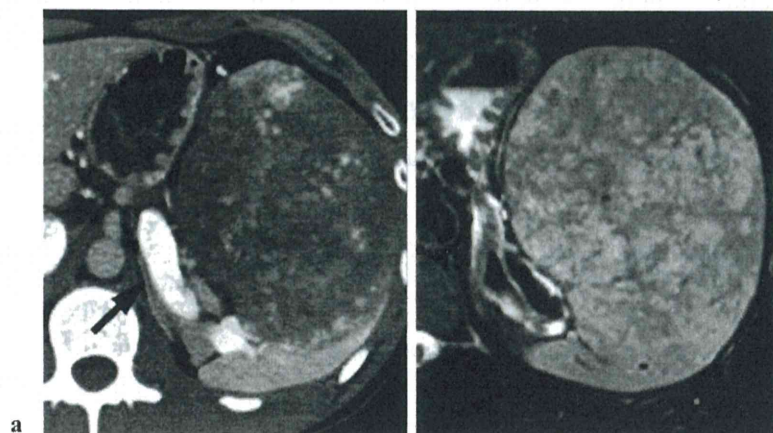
(a) Abdominal CT showing an enhanced splenic tumor with a gradual centripetal fill-in pattern and dilated splenic vein (arrow). (b) T₂-weighted MRI showing a high-intensity splenic tumor.
